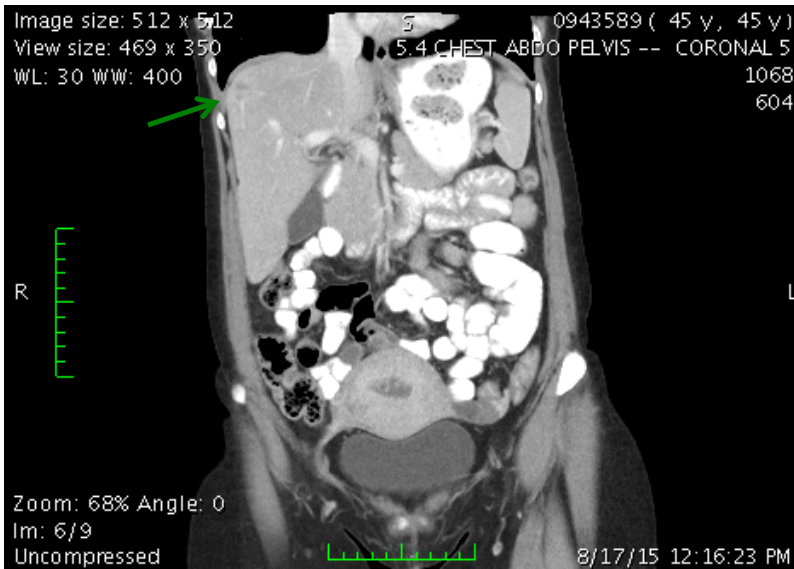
CT scan of abdomen & pelvis - August 2015
